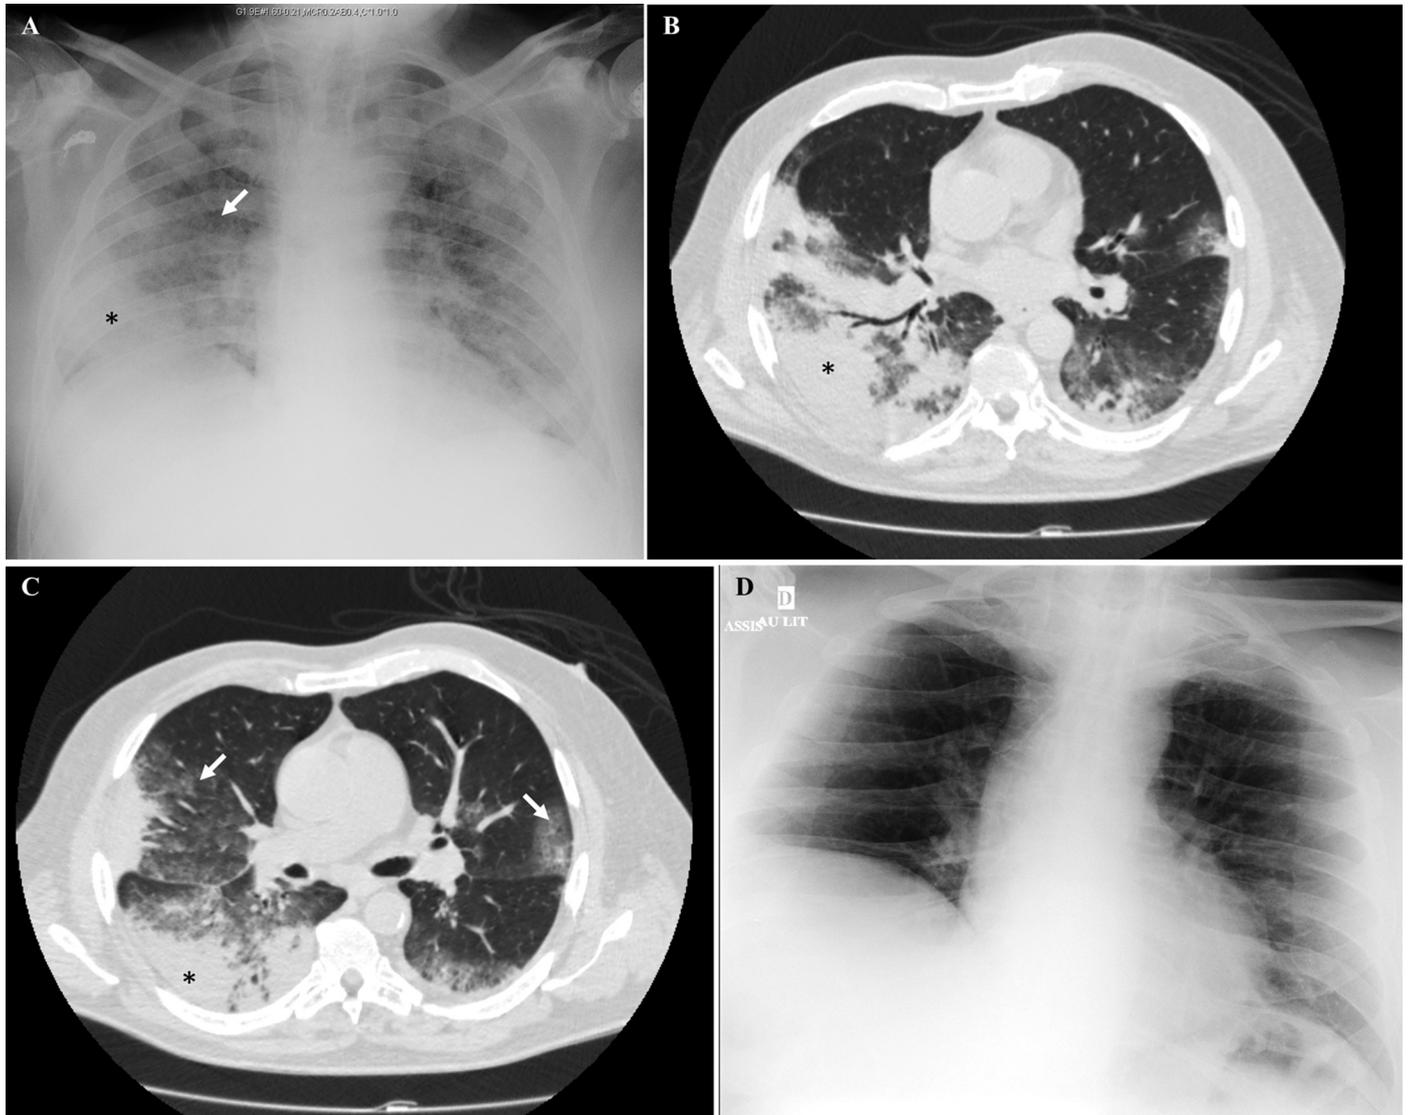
Initial chest X-ray (panel A) and CT scans (panels B and C) showing diffuse alveolar (asterisks) and interstitial (arrows) opacities. A follow-up X-ray showed normalization at 3 weeks after daptomycin cessation (panel D).
